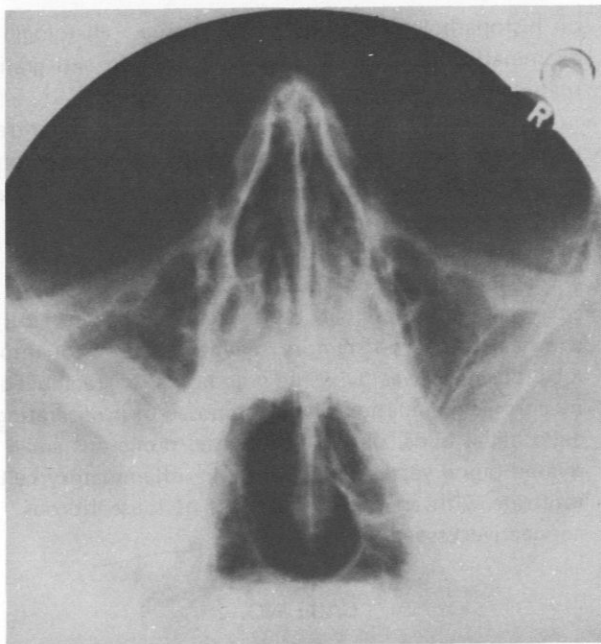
X-ray examination, Waters view, reveals mass in the left posterior maxillary antrum presented in Case No. 2.
